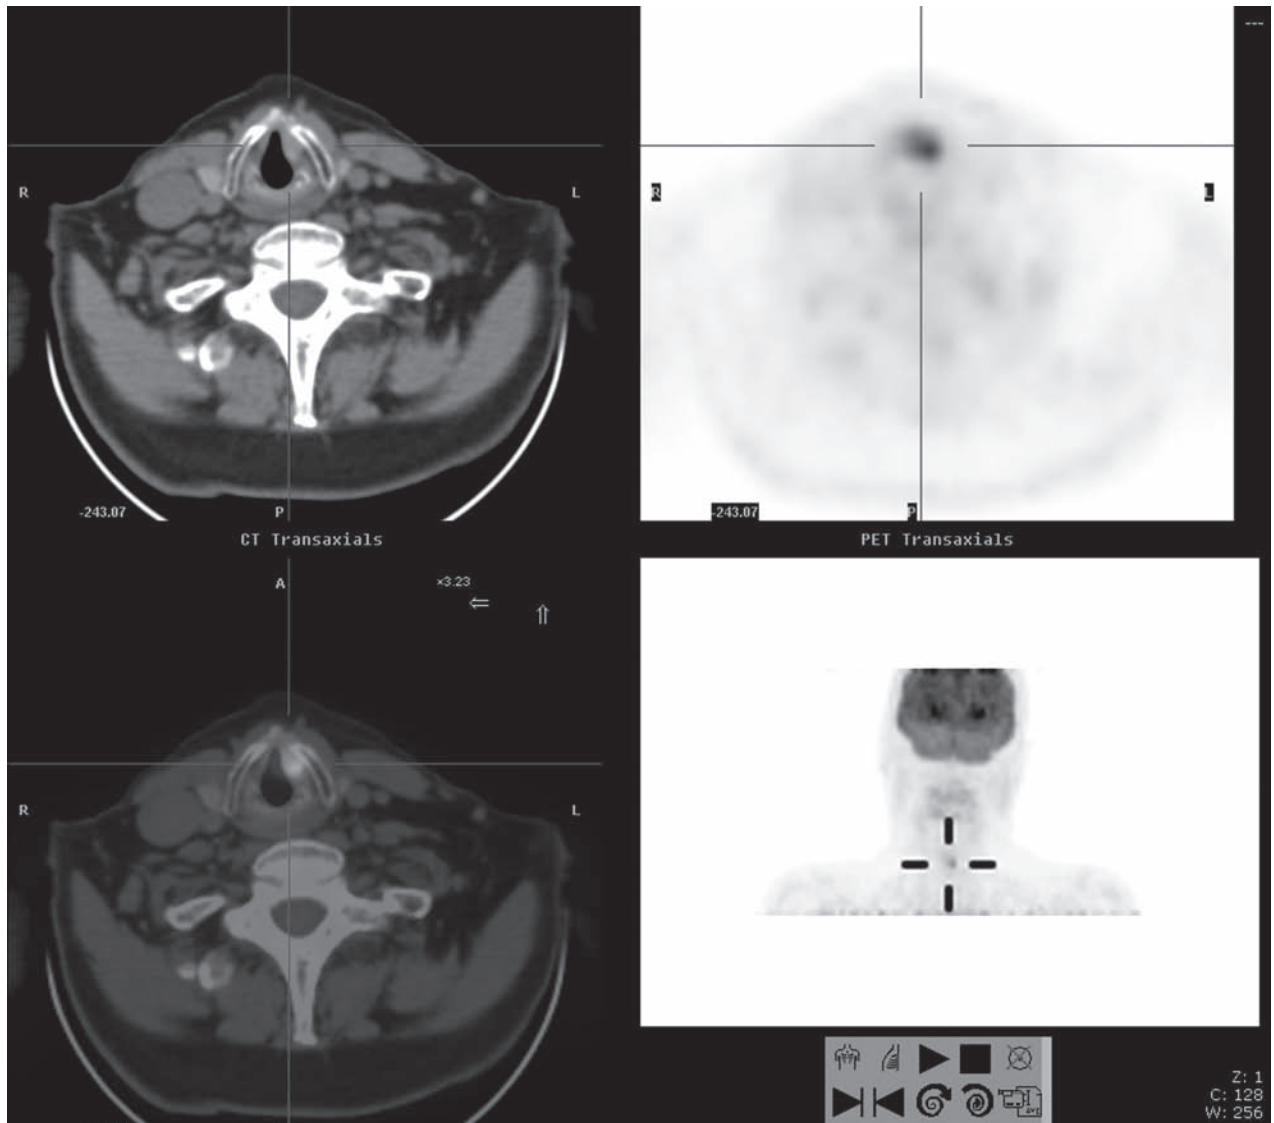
Axial slices of PET/CT show increased activity in the right basal tongue indicated by the lines. The image in the lower right corner shows a three-dimensional volume display with increased activity at the same point in the axial slices
